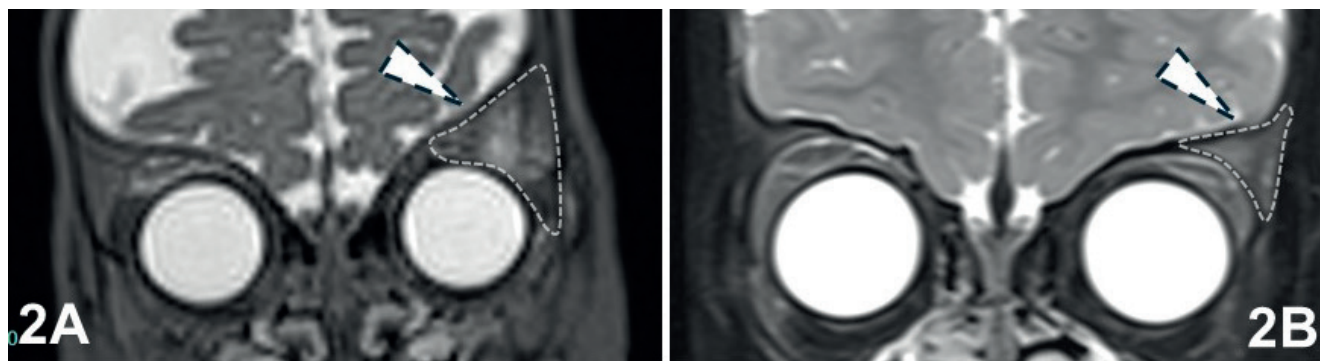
(A) MRI section at 8 months of age showing intraosseous tissular lesion with intense and homogeneous enhancement. (B) MRI section 30 months of age showing complete regression of infantile haemangioma.
